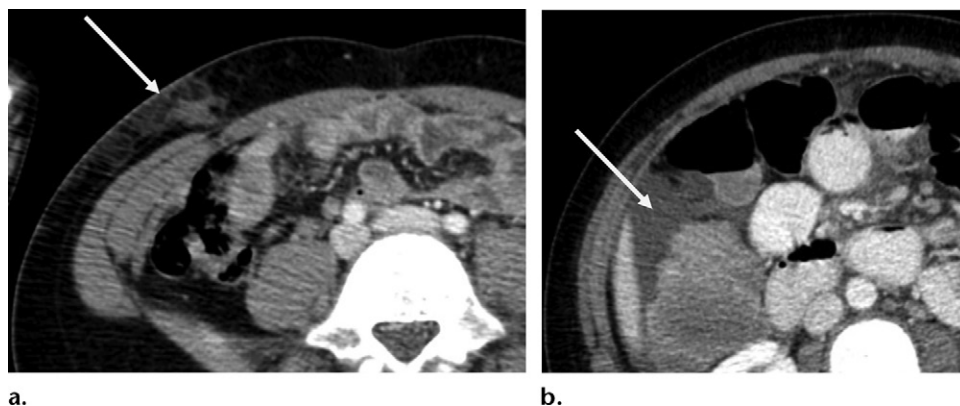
Free fluid in an 8-year-old boy who presented with abdominal pain after a motor vehicle collision. (a) Initial axial multidetector CT image obtained at the time of the motor vehicle collision shows a contusion (arrow) in the subcutaneous tissues of the anterior abdominal wall (the so-called seat-belt sign) and a trace of hyperattenuating intraperitoneal fluid in the pelvis. Because of ongoing abdominal symptoms, the patient underwent a repeat CT examination 3 days later with oral contrast material administration. (b) Repeat axial contrast-enhanced CT image shows an increased amount of free fluid (arrow). Although extraluminal oral contrast material was not identified, the presence of an increasing amount of hyperattenuating free fluid raised suspicion for bowel injury. At laparotomy, a jejunal perforation was discovered and primarily repaired, without the need for resection.
